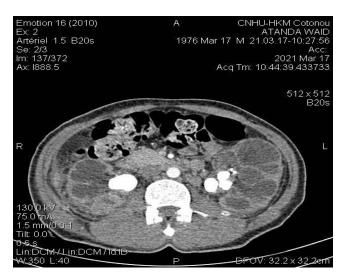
CT image of bilateral renal pelvis stone; on the right are multiple bilateral renal calculi, and on the left are five stones, the largest measuring 4.8 mm and 1 273 UH in density
